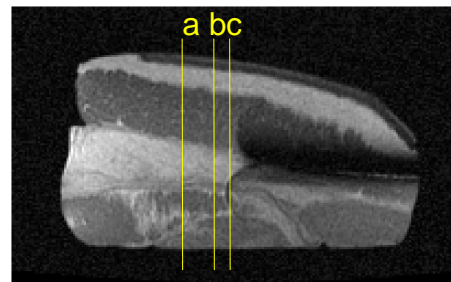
Spin echo MR image shows approximate slice locations for ablation electrode current density reconstruction.
